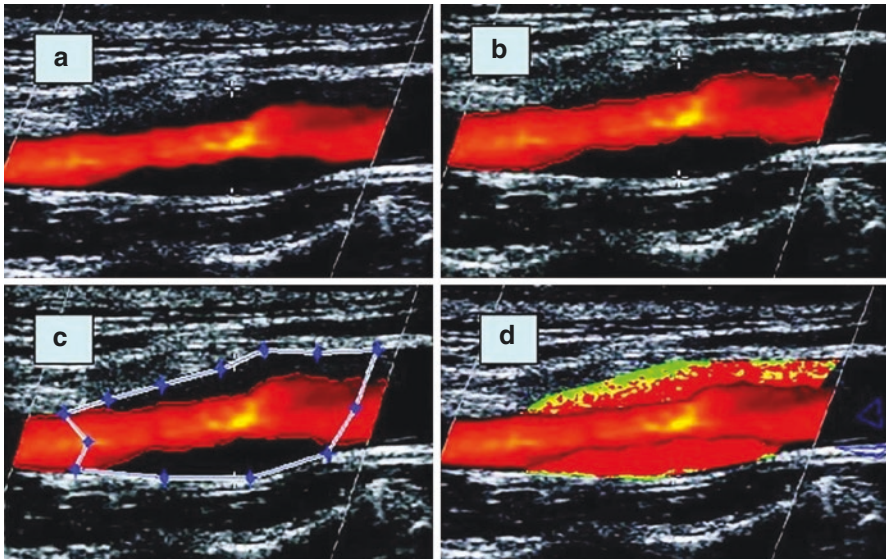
Ultrasound image of the carotid plaque in an asymptomatic patient. (a) Note the different echogenic characteristics of the plaque (anechoic in the far wall and more echogenic in the near wall region). (b) The color flow is automatically outlined (see red lines); the limit represents the border zone between the surface of the plaque and the color flow. (c) Manual delineation of the plaque according to the threshold: <60 (red), 60–90 (yellow), and >90 (green). The surface is delineated automatically between 0 and 0.5 mm, 0 and 1 mm, 0 and 1.5 mm, and 0 and 2 mm. Also note the normalization of the plaque (selection of the darkest and the brightest regions 0–190 with blue triangles). (Reprinted from Sztajzel [87]. With permission from Springer Nature)
